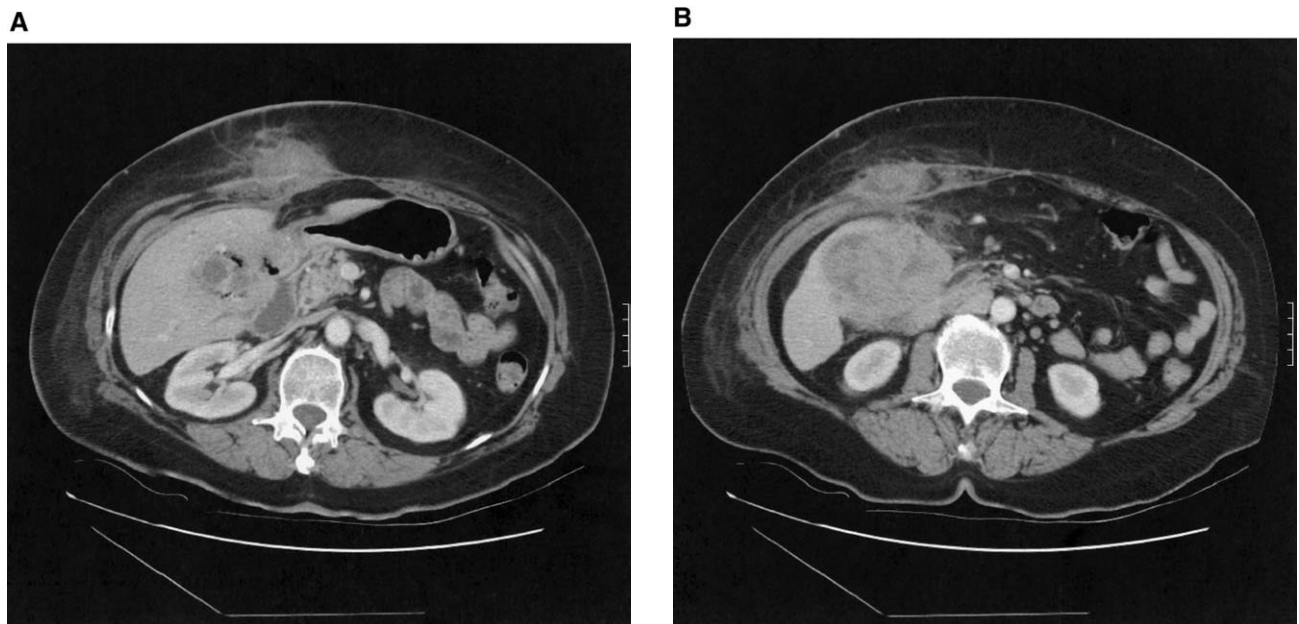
(A) Abdominal CT with intravenous contrast shows a moderate number of pericholecystic gas-filled collections and mild prominence of the proximal intrahepatic ductal system and extrahepatic ducts. (B) This image demonstrates the large pericholecystic heterogeneous soft tissue mass measuring approximately 6.4×8.2 cm in maximal transverse diameter.
